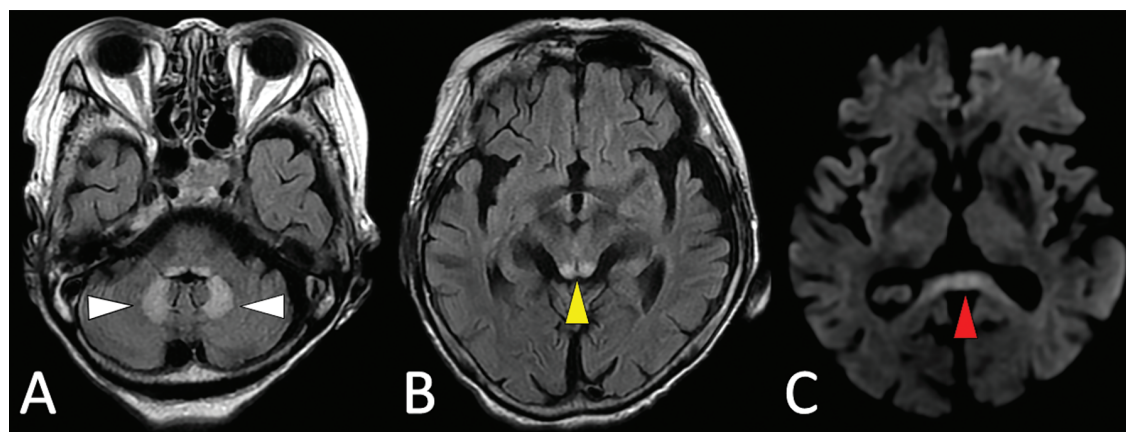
(A) T2 fluid-attenuated inversion recovery (T2-FLAIR) on MRI shows typical symmetrical hyperintensity in the dentate nuclei of the cerebellum, reflecting vasogenic edema (white arrowheads). (B) T2-FLAIR MRI shows hyperintensity in the tectum of the midbrain (yellow arrowhead). (C) Diffusion-weighted MRI shows hyperintensity in the splenium of the corpus callosum, indicating restricted diffusion or cytotoxic edema (red arrowhead).
